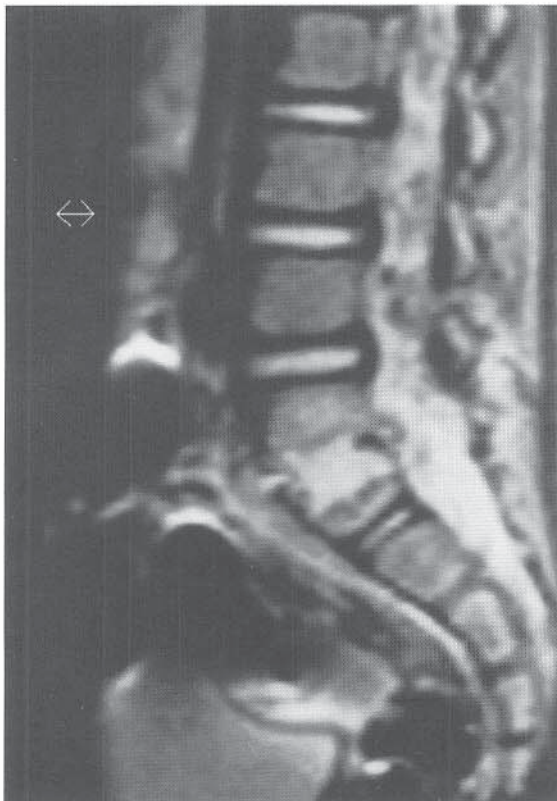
MRI of L5-S1 diskitis. Note the increased signal intensity of the entire disk space as well as both end-plates.
